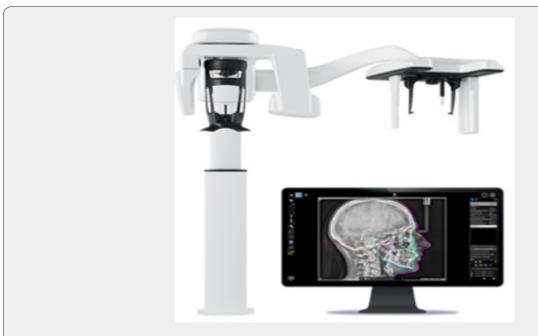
Basic operation process CBCT tomography technique.
